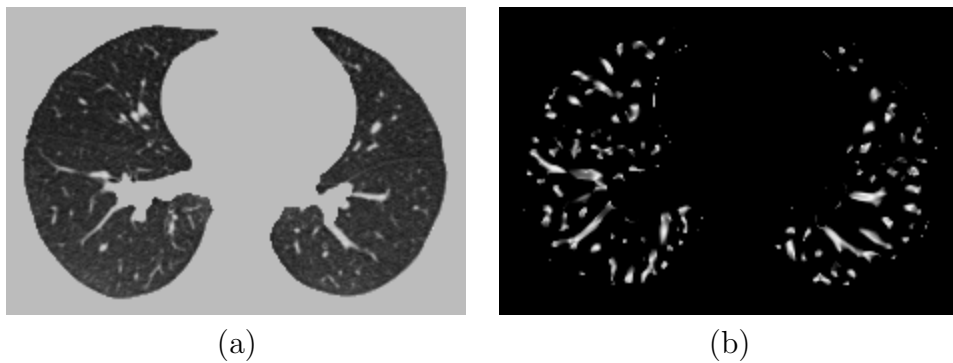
The vesselness images calculated from lung CT grayscale images. (a) A transverse slice of FRC data. (b) The vesselness measure of slice in (a). Vesselness measure is computed in multiscale analysis and rescaled to $[0, 1]$.
